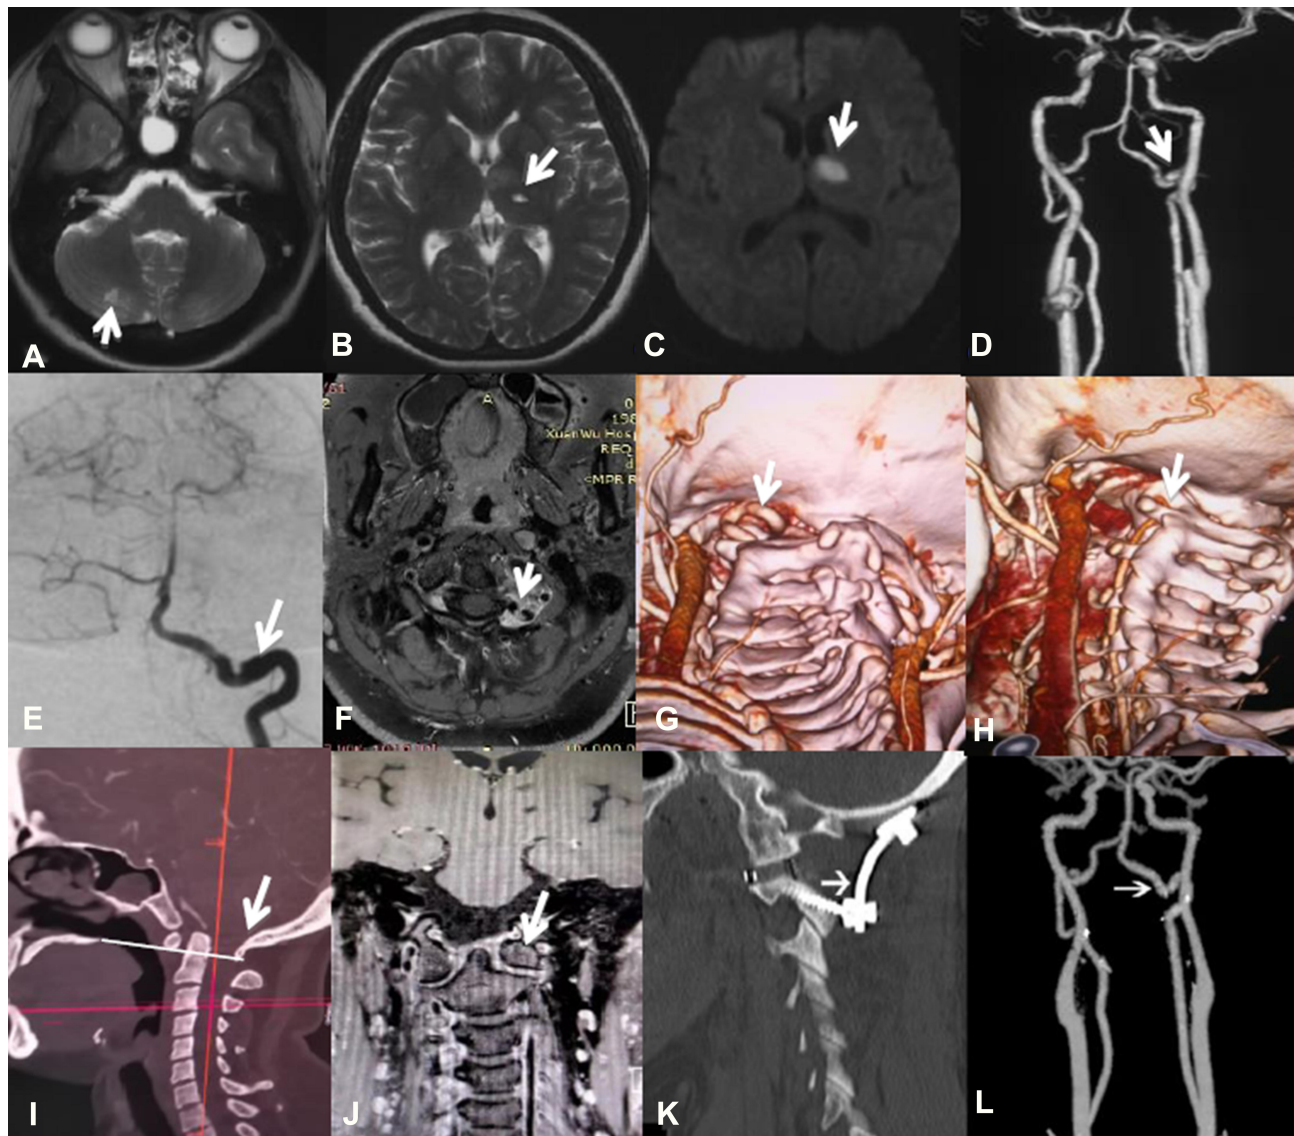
(A–C) MRI showing new infarction in the left anterior thalamus and old infarction in the left thalamus and right cerebellum (white arrow); (D, E) CTA and DAS showing a local protuberance at the junction of V3 and V4 in the left VA, thought to be dissection (white arrow); (F) high-resolution MRI showing an endovascular membrane-like structure protruding into the lumen at the junction of V3 and V4 in the left VA (white arrow); (G, H) head CTA showing that the left VA was normal (white arrow) with the neck in a neutral position and occlusive (white arrow) far from the C2 transverse foramen with the head turned right; (I) cervical CT showing atlanto-occipital fusion (white arrow) and the odontoid process of axis exceeded the palato-occipital line by >3 mm, considered skull-base depression; (J) MRI showing left-atlas lateral mass to be small with dysplasia (white arrow); (K) cervical CT showing atlantoaxial fusion (white arrow) had been performed on this patient; (L) repeat CTA showing that the small protuberance at the V3–V4 junction of the left VA had disappeared (white arrow).
